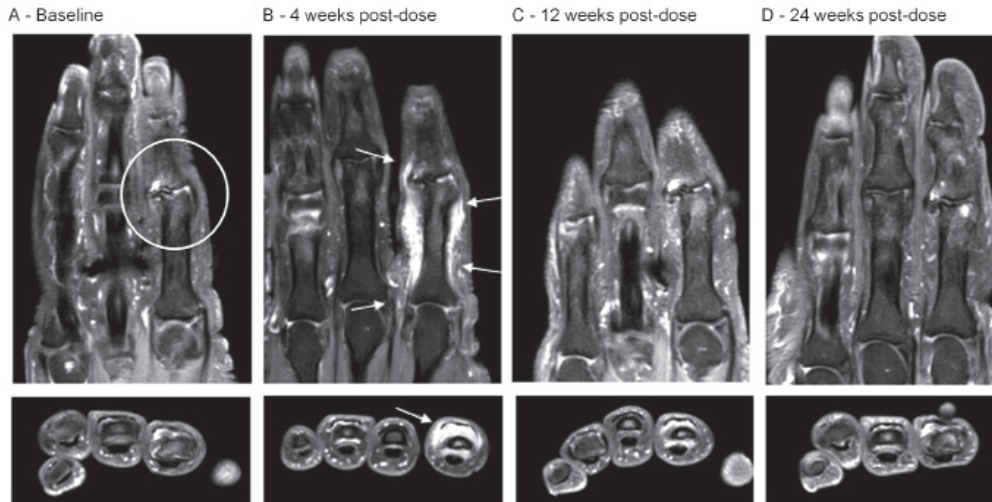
MRIs of patient 4 MRI of the target joint, the proximal interphalangeal joint of the second digit (PIP dig. II) of the left hand, of patient 4, at four different time points during the study. T1-weighted, fat suppressed, Gadolinium-enhanced images, in corresponding coronal- and axial planes shown vertically. Panel A. Baseline scan, showing definite osteoarthritis of PIP II, with minimal synovitis (circle) and an enhancing synovial cyst in the ulnar base of the middle phalanx. The synovitis and cysts are also reflected in the axial plane (bottom pane). Panel B. Scan at 4 weeks after study drug administration, showing substantial increase of swelling of the finger with synovitis in the PIP II joint and peri-arthritis with increased swelling around the extensor tendon and of the soft tissues along the proximal interphalangeal phalanx to the second metacarpophalangeal (MCP II) joint (arrows). The extensive peri-arthritis is also well recognized in the axial plane (bottom pane, arrow). Panel C. Scan at 12 weeks after study drug administration: minimally remaining synovitis, reduction of the peri-arthritis. Panel D. Scan at 24 weeks after study drug administration, image similar compared to baseline (Vitamin capsule as marker in situ).
